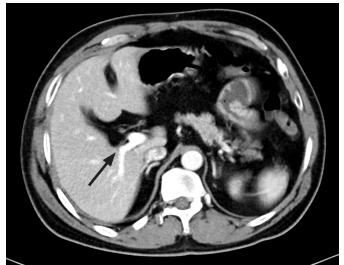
Axial CT scan showing RPPV as first branch of portal vein.
